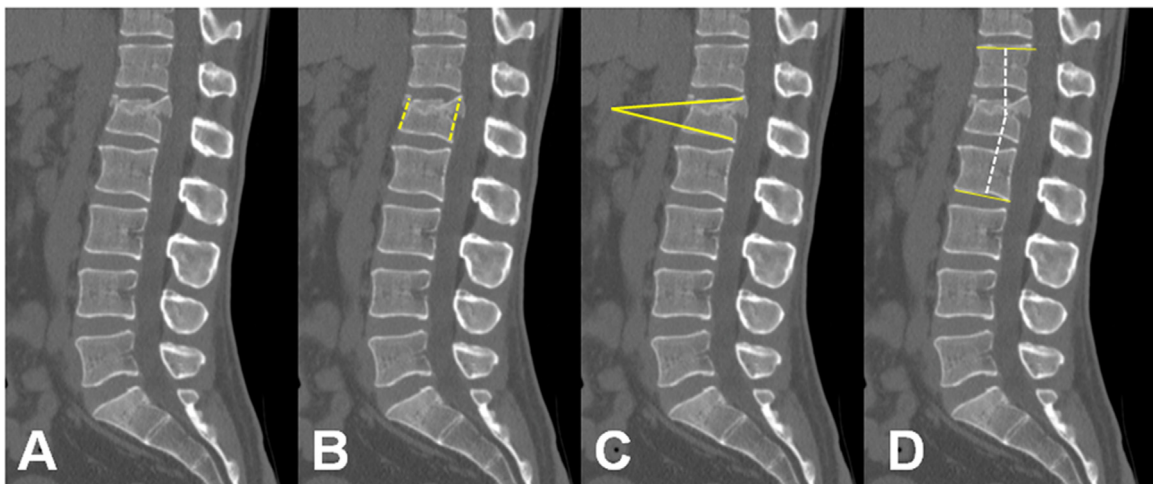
(A), Sagittal spine CT scan before surgery to classify fracture. (B), Vertebral body compression ration (beck index). (C), vertebral wedge angle (Farcy angle), (D) Cobb angle were measured on standing radiographs and initial CT scan.
